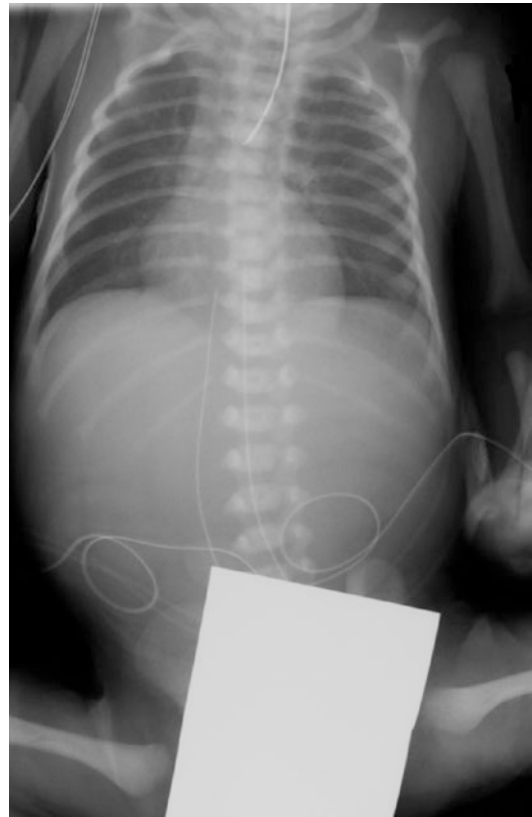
This newborn has the classic radiograph for isolated esophageal atresia. Note the esophageal tube cannot be passed further than the proximal esophagus and there is no air in the abdomen
